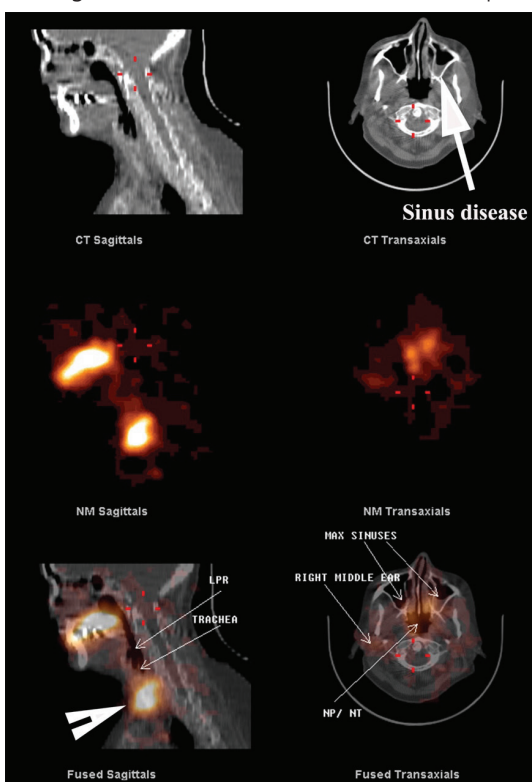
SPECT/CT image of head and neck. The upper panel of CT images demonstrates evidence of sinus disease in the left maxillary sinus. Fused images in the lower panel confirm the presence of refluxate contaminating the LPR, trachea, maxillary sinuses, NP, nasal NT and the right middle ear. The middle panel demonstrates the scintigraphic images and the difficulty in ascribing anatomical sites to these images without the CT study. Note uptake in the thyroid gland (arrowhead) in the fused sagittal image due to breakdown of the radiopharmaceutical in the delayed images
